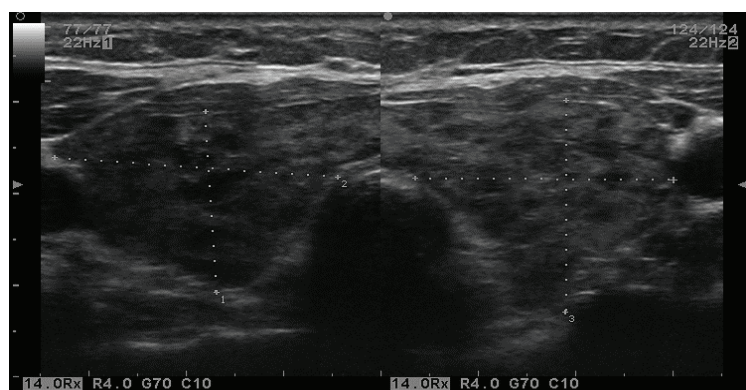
Typical ultrasound image of autoimmune thyroid disease with marked diffuse hypoechogenicity of the parenchyma and fibrotic changes
